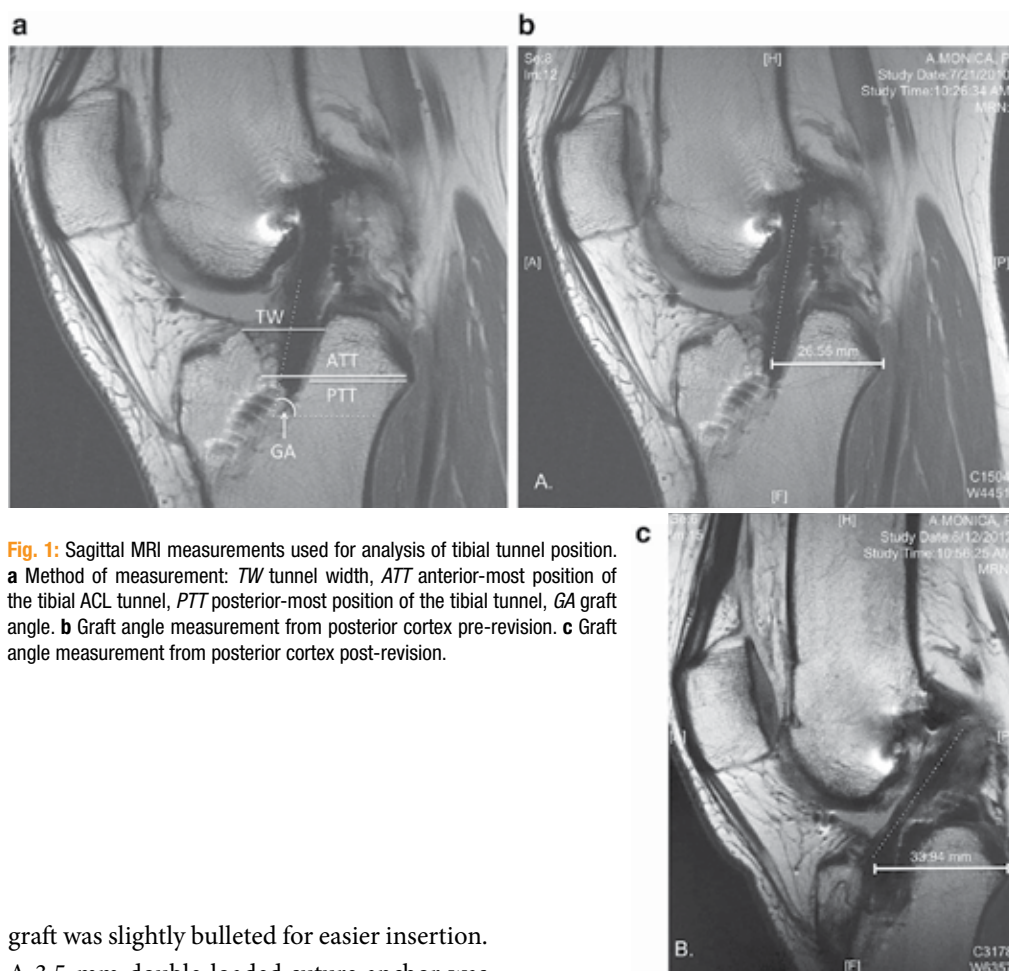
Sagittal MRI measurements used for analysis of tibial tunnel position. a Method of measurement: *TW* tunnel width, *ATT* anterior-most position of the tibial ACL tunnel, *PTT* posterior-most position of the tibial tunnel, *GA* graft angle. b Graft angle measurement from posterior cortex pre-revision. c Graft angle measurement from posterior cortex post-revision.
